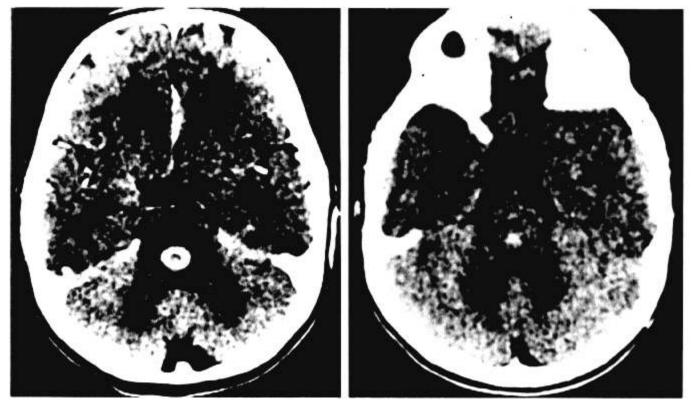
(Case 3) (Left) CT scan shows pontine lesion with contrast enhancement. (Right) After seven months of antituberculous therapy, CT scan shows only punctate calcifications remaining.
